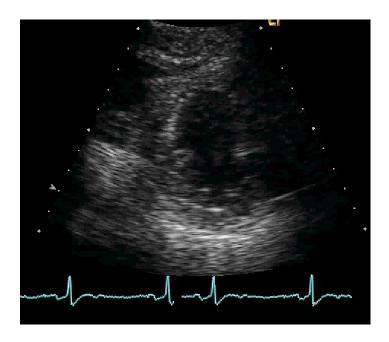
The same patient as in figure 5 showing no flattening of the septum in short axis view of echocardiographic image
